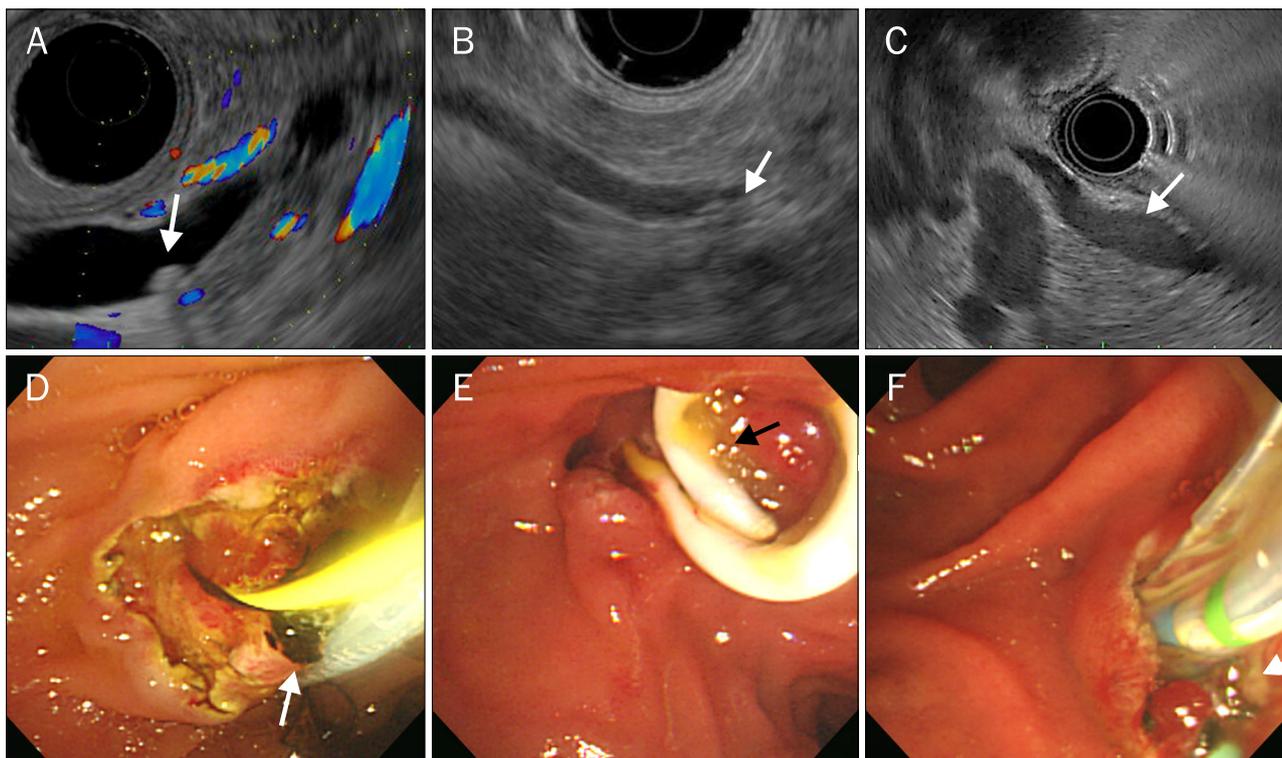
Endosonographic and endoscopic findings of choledocholithiasis. Endosonography revealed the presence of hyperechoic foci in the common bile duct; posterior shadowing (arrows) indicated choledocholithiasis (A, B), and amorphous materials in the common bile duct without posterior shadowing (arrow) indicated sludge (C). Endoscopy showed the presence of a single dark brown stone, which was extracted after endoscopic sphincterotomy (arrow) (D), and the presence of yellow amorphous material (sludge), which was drained during endoscopic retrograde cholangiopancreatography (arrows) (E, F).
